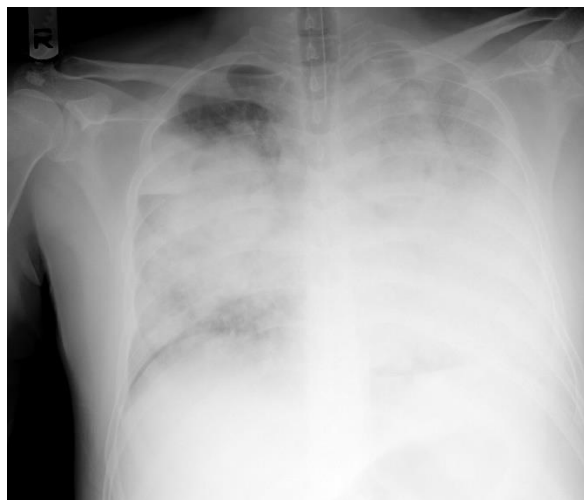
Chest X-ray of the patient on May 1, 2020, showing bilateral diffuse interstitial pulmonary edema with left-sided pleural effusion
